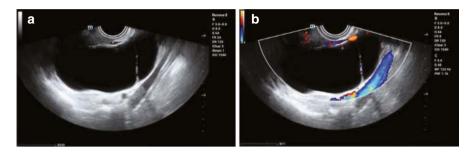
(a) B-mode ultrasound reveals a simple serous ovarian cystadenoma characterized by a well-defined, ovoid shape, smooth inner walls, and a single septum. (b) Color Doppler ultrasound reveals blood flow signals in the cystic wall and septum
